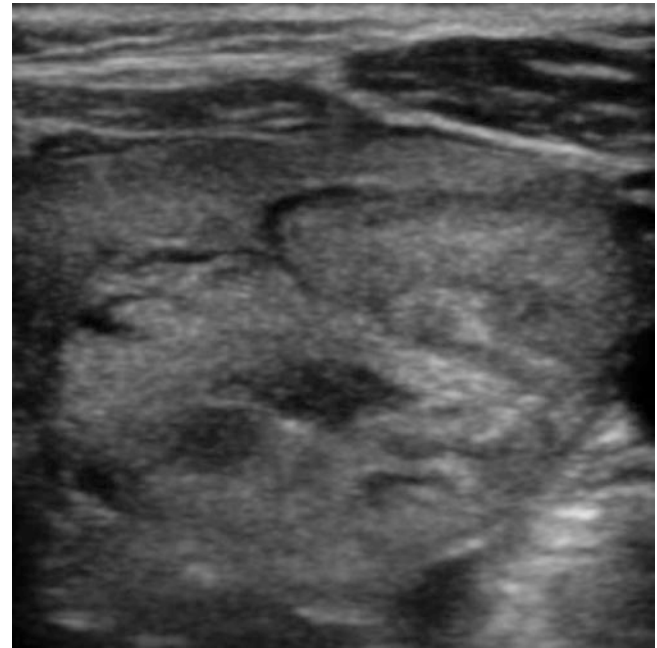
A thyroid mass (M) is seen on the image. Note the heterogeneous echogenicity and the abnormal contour of the thyroid. Ultrasound is sensitive in diagnosing malignant lesions of the thyroid. Image courtesy of Mangala Narasimhan
